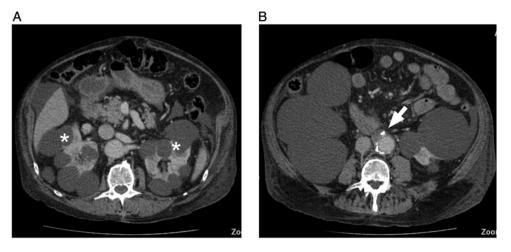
Abdominal CT scan. (A) Cystic change bilaterally within kidneys suggestive of ADPKD. Cystic kidneys are marked with asterisks. (B) Soft tissue mass (arrowed) anterior to the aortic graft suggestive of graft aortitis.
